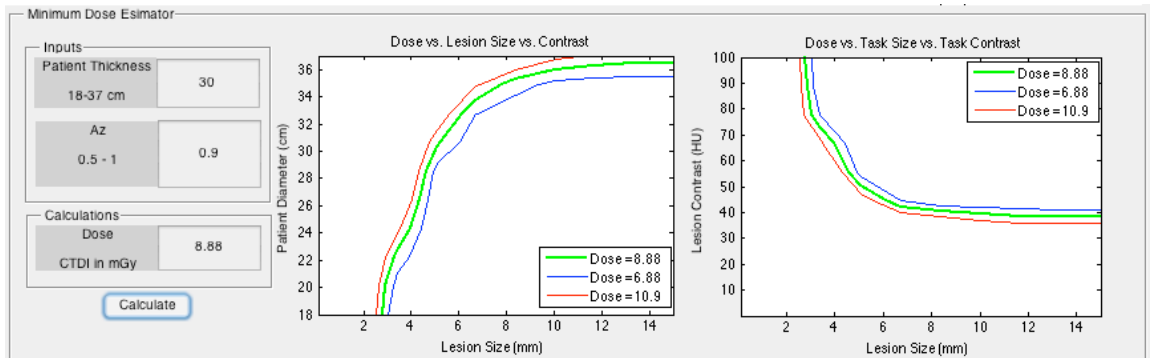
Example of the minimum dose estimator section of the CT protocol evaluator platform.
